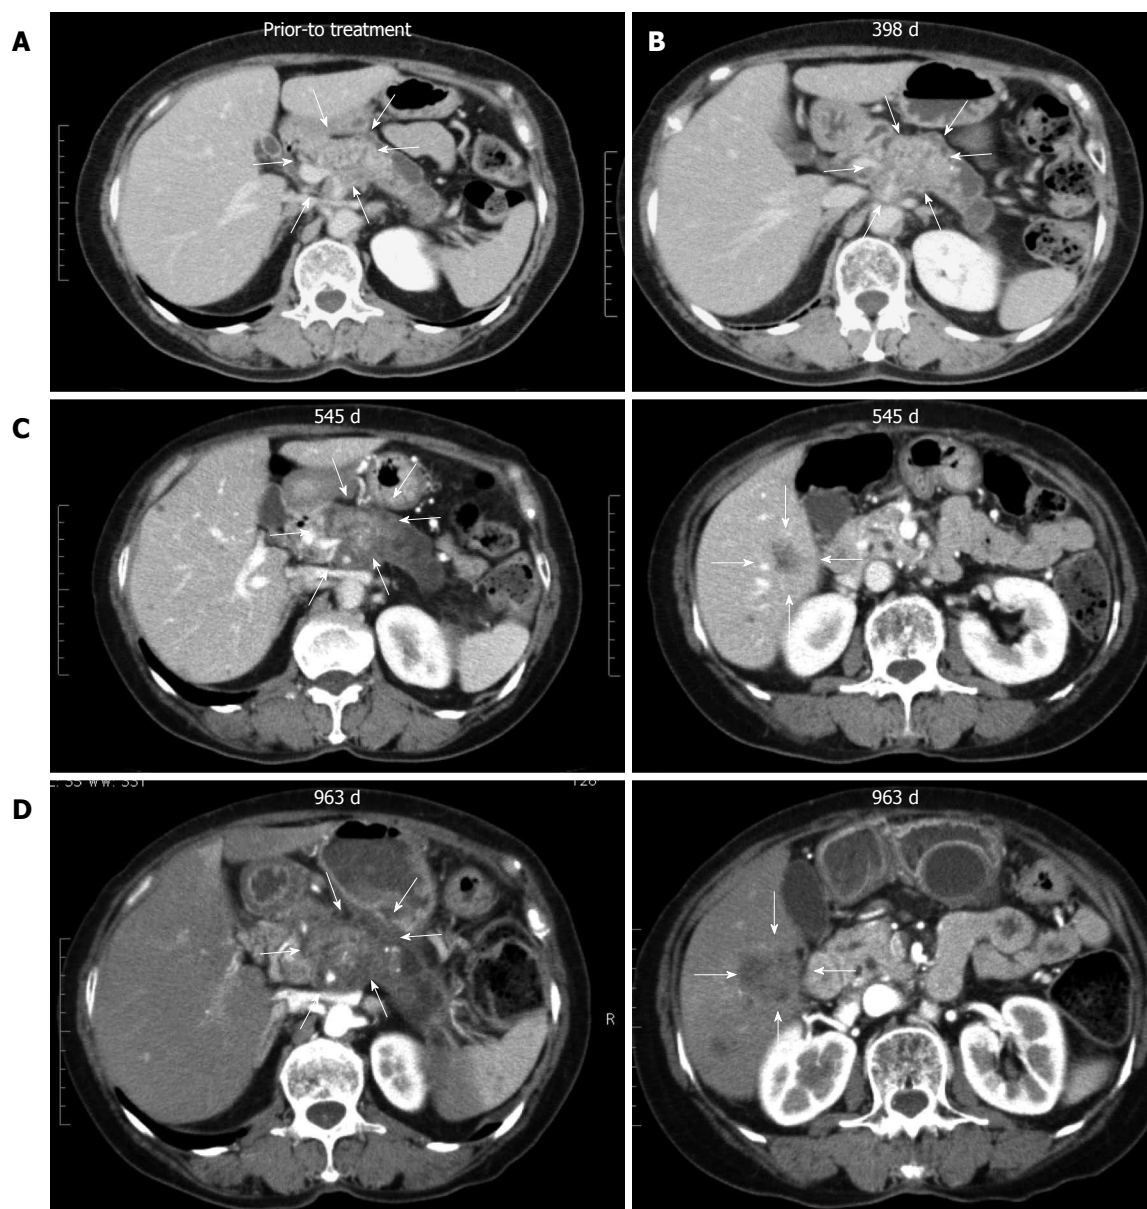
Response assessment in a super-responder, case 6. A: Computed tomography (CT) imaging of case 6 revealing pancreatic body cancer before treatment and no liver metastases; B: CT imaging after chemoimmunotherapy revealed that local pancreatic lesions were stable; C: Local pancreatic lesions were stable (left panel), multiple liver metastases appeared at 545 d after the first treatment (right panel); D: Local pancreatic lesions were stable (left panel), the sizes of multiple liver metastases were markedly increased at 963 d after the first treatment (right panel).
